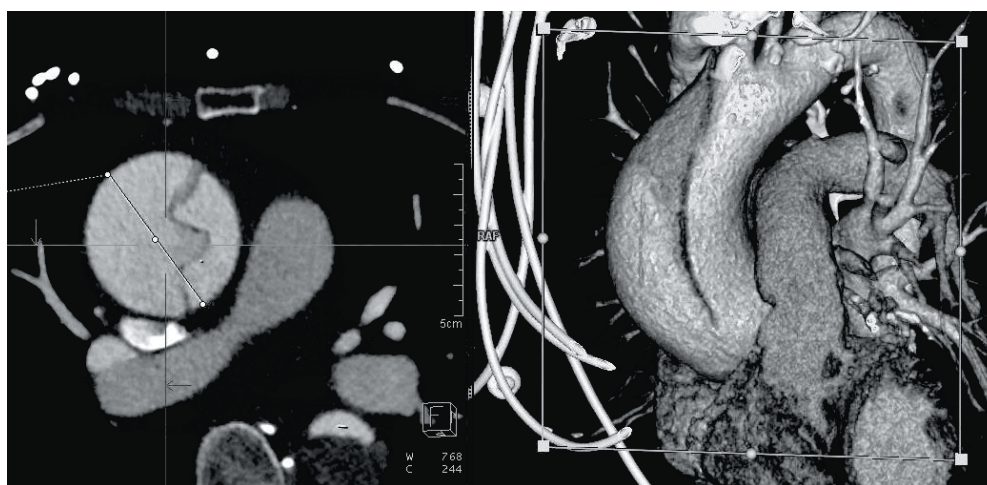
CT angiography showing the Stanford Type A dissection of the aorta
